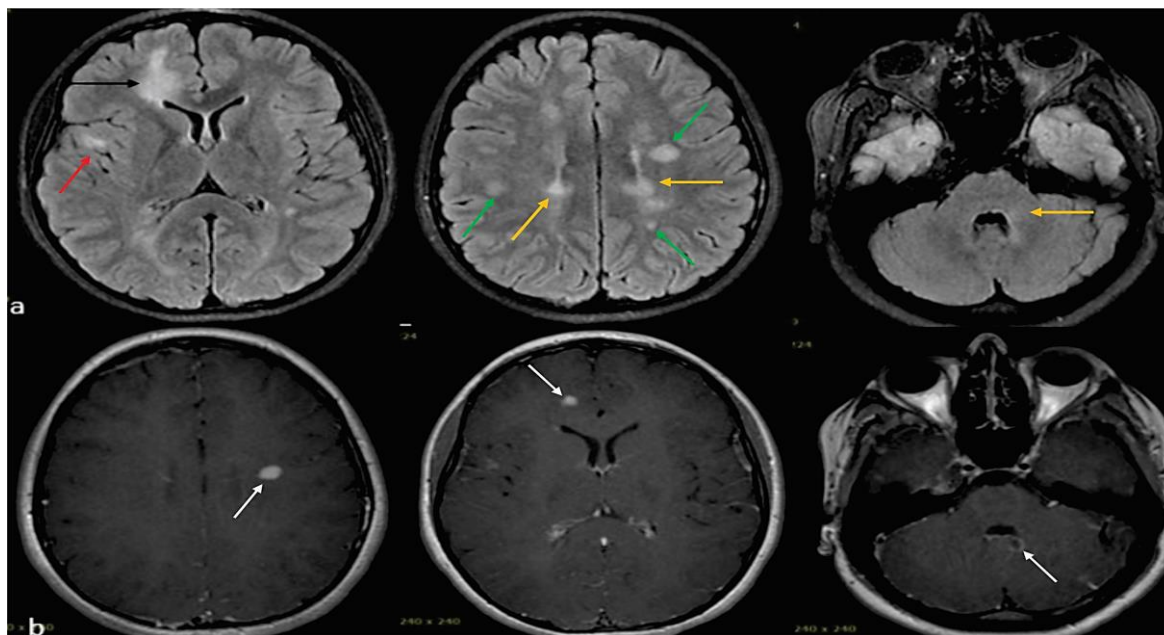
Patient 5; (a) multiple ovoid hyperintense lesions in juxtacortical (red arrow), subcortical (green arrows), and periventricular (yellow arrows, third and fourth ventricle) locations in axial T2-weighted fluid-attenuated inversion recovery (FLAIR), and one tumefactive-like lesion (black arrow), (b) evidence of gadolinium enhancement in some of the lesions (white arrows)
